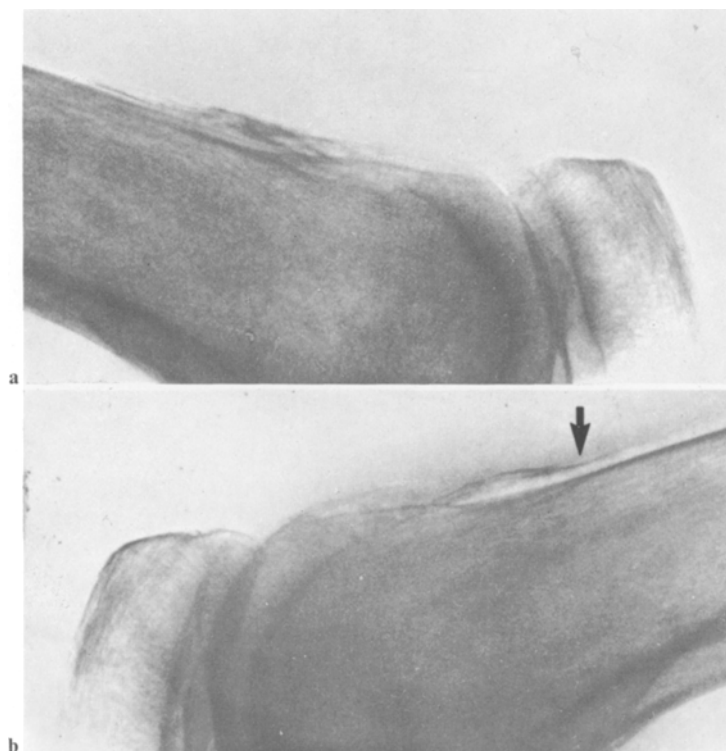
a and b. Roentgenographic profile view (April 24, 1974). a Right knee; b Left knee
